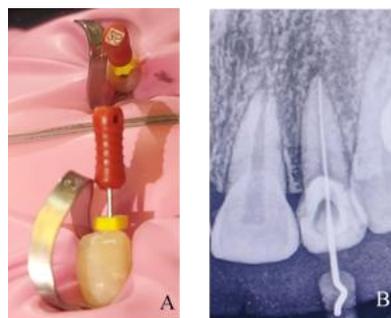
Working Length Confirmation. A: Clinical View. B: Radiographic View
